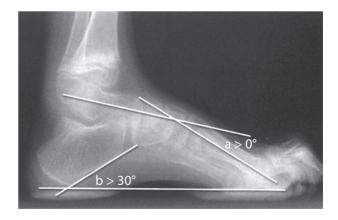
Weight-bearing X-rays in foot deformities Non-weight-bearing films are notorious for 'hiding' the true components of foot deformities. In standing lateral views, some measurements are useful in describing the type of high-arched foot: (a) the axes of the talus and first metatarsal are parallel in normal feet but cross each other in a plantaris deformity (Meary's angle); (b) the calcaneal pitch is greater than 30 degrees in calcaneus deformities.
